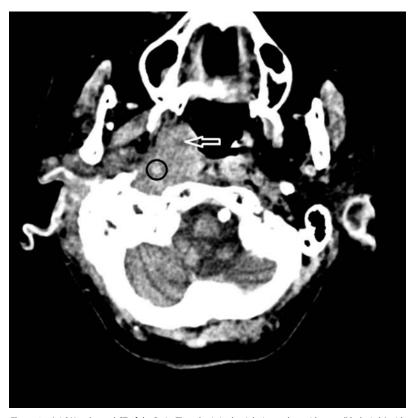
Axial Unenhanced CT of the Brain: Thrombosis in the right internal carotid artery (black circle) with surrounding tumour in the nasopharyngeal recess (white arrow).
